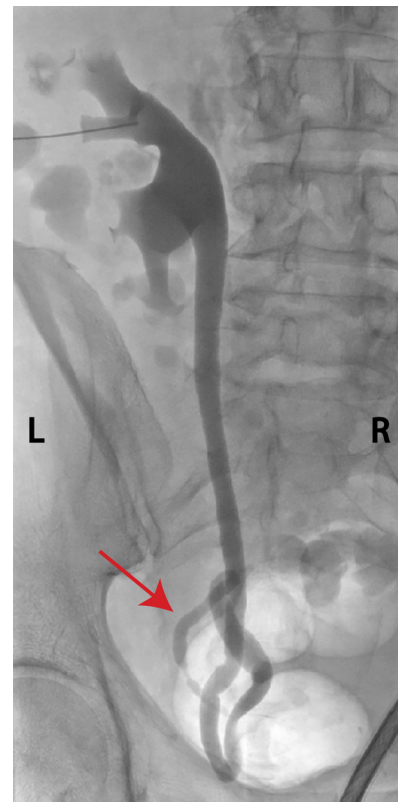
Antegrade nephrostogram showing dilated, tortuous left ureter with absence of contrast enhancement of bladder, indicating obstruction due to ureteral herniation into the inguinal canal. (A) Prone radiograph showing redundant ureter (red arrow) entering the hernia sac.
